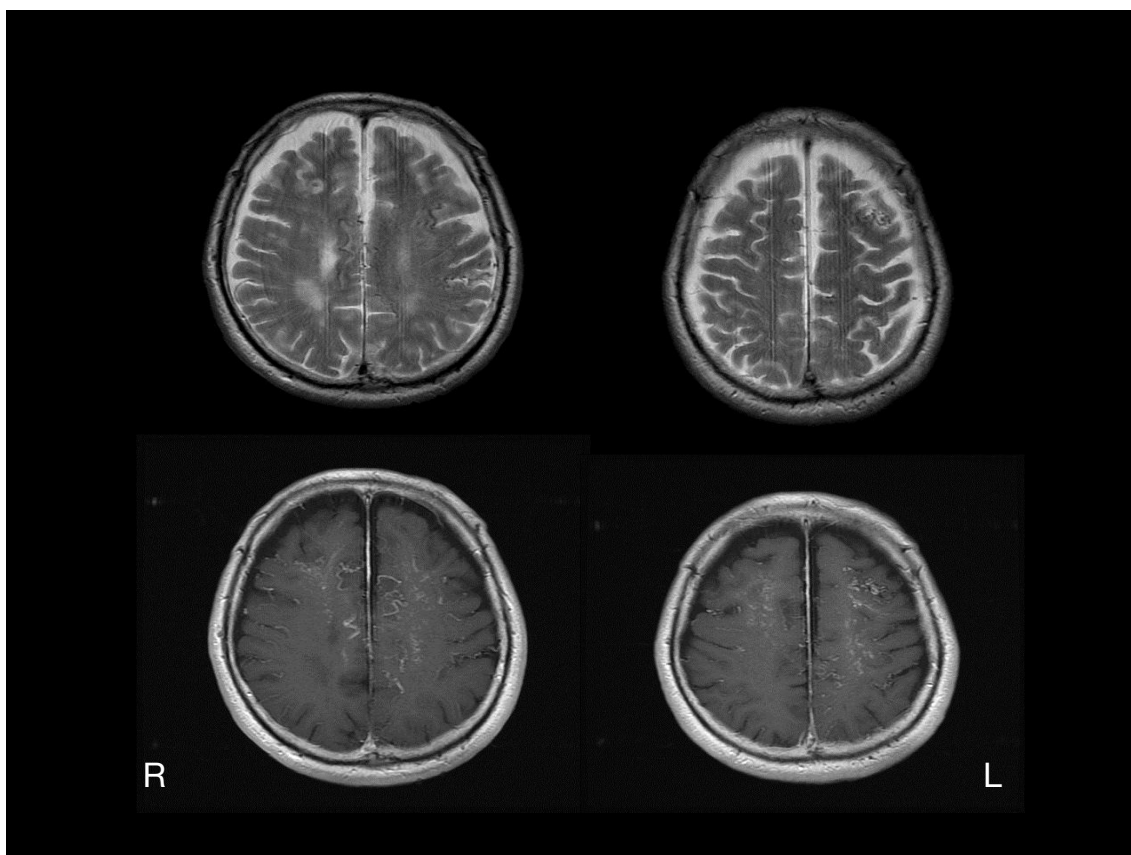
Detailed MR images. T2-weighted (top) and contrast-enhanced T1-weighted (bottom) MR images show dilated cortical veins in both cerebral hemispheres.
